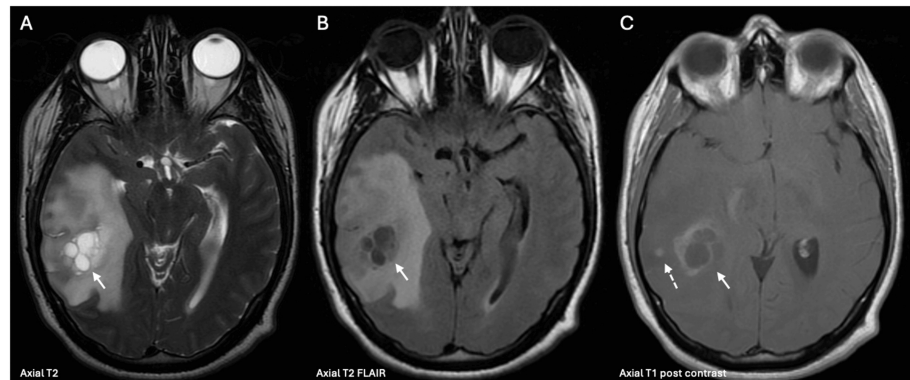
Brain MRI images
